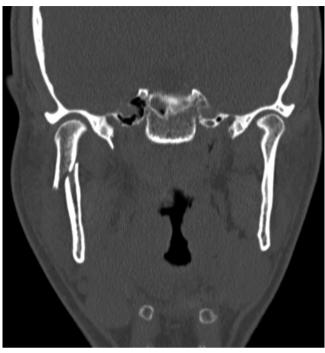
CT imaging confirms a favourable fracture configuration for ORIF. Telescoping is evident and the patient had dysocclusion
